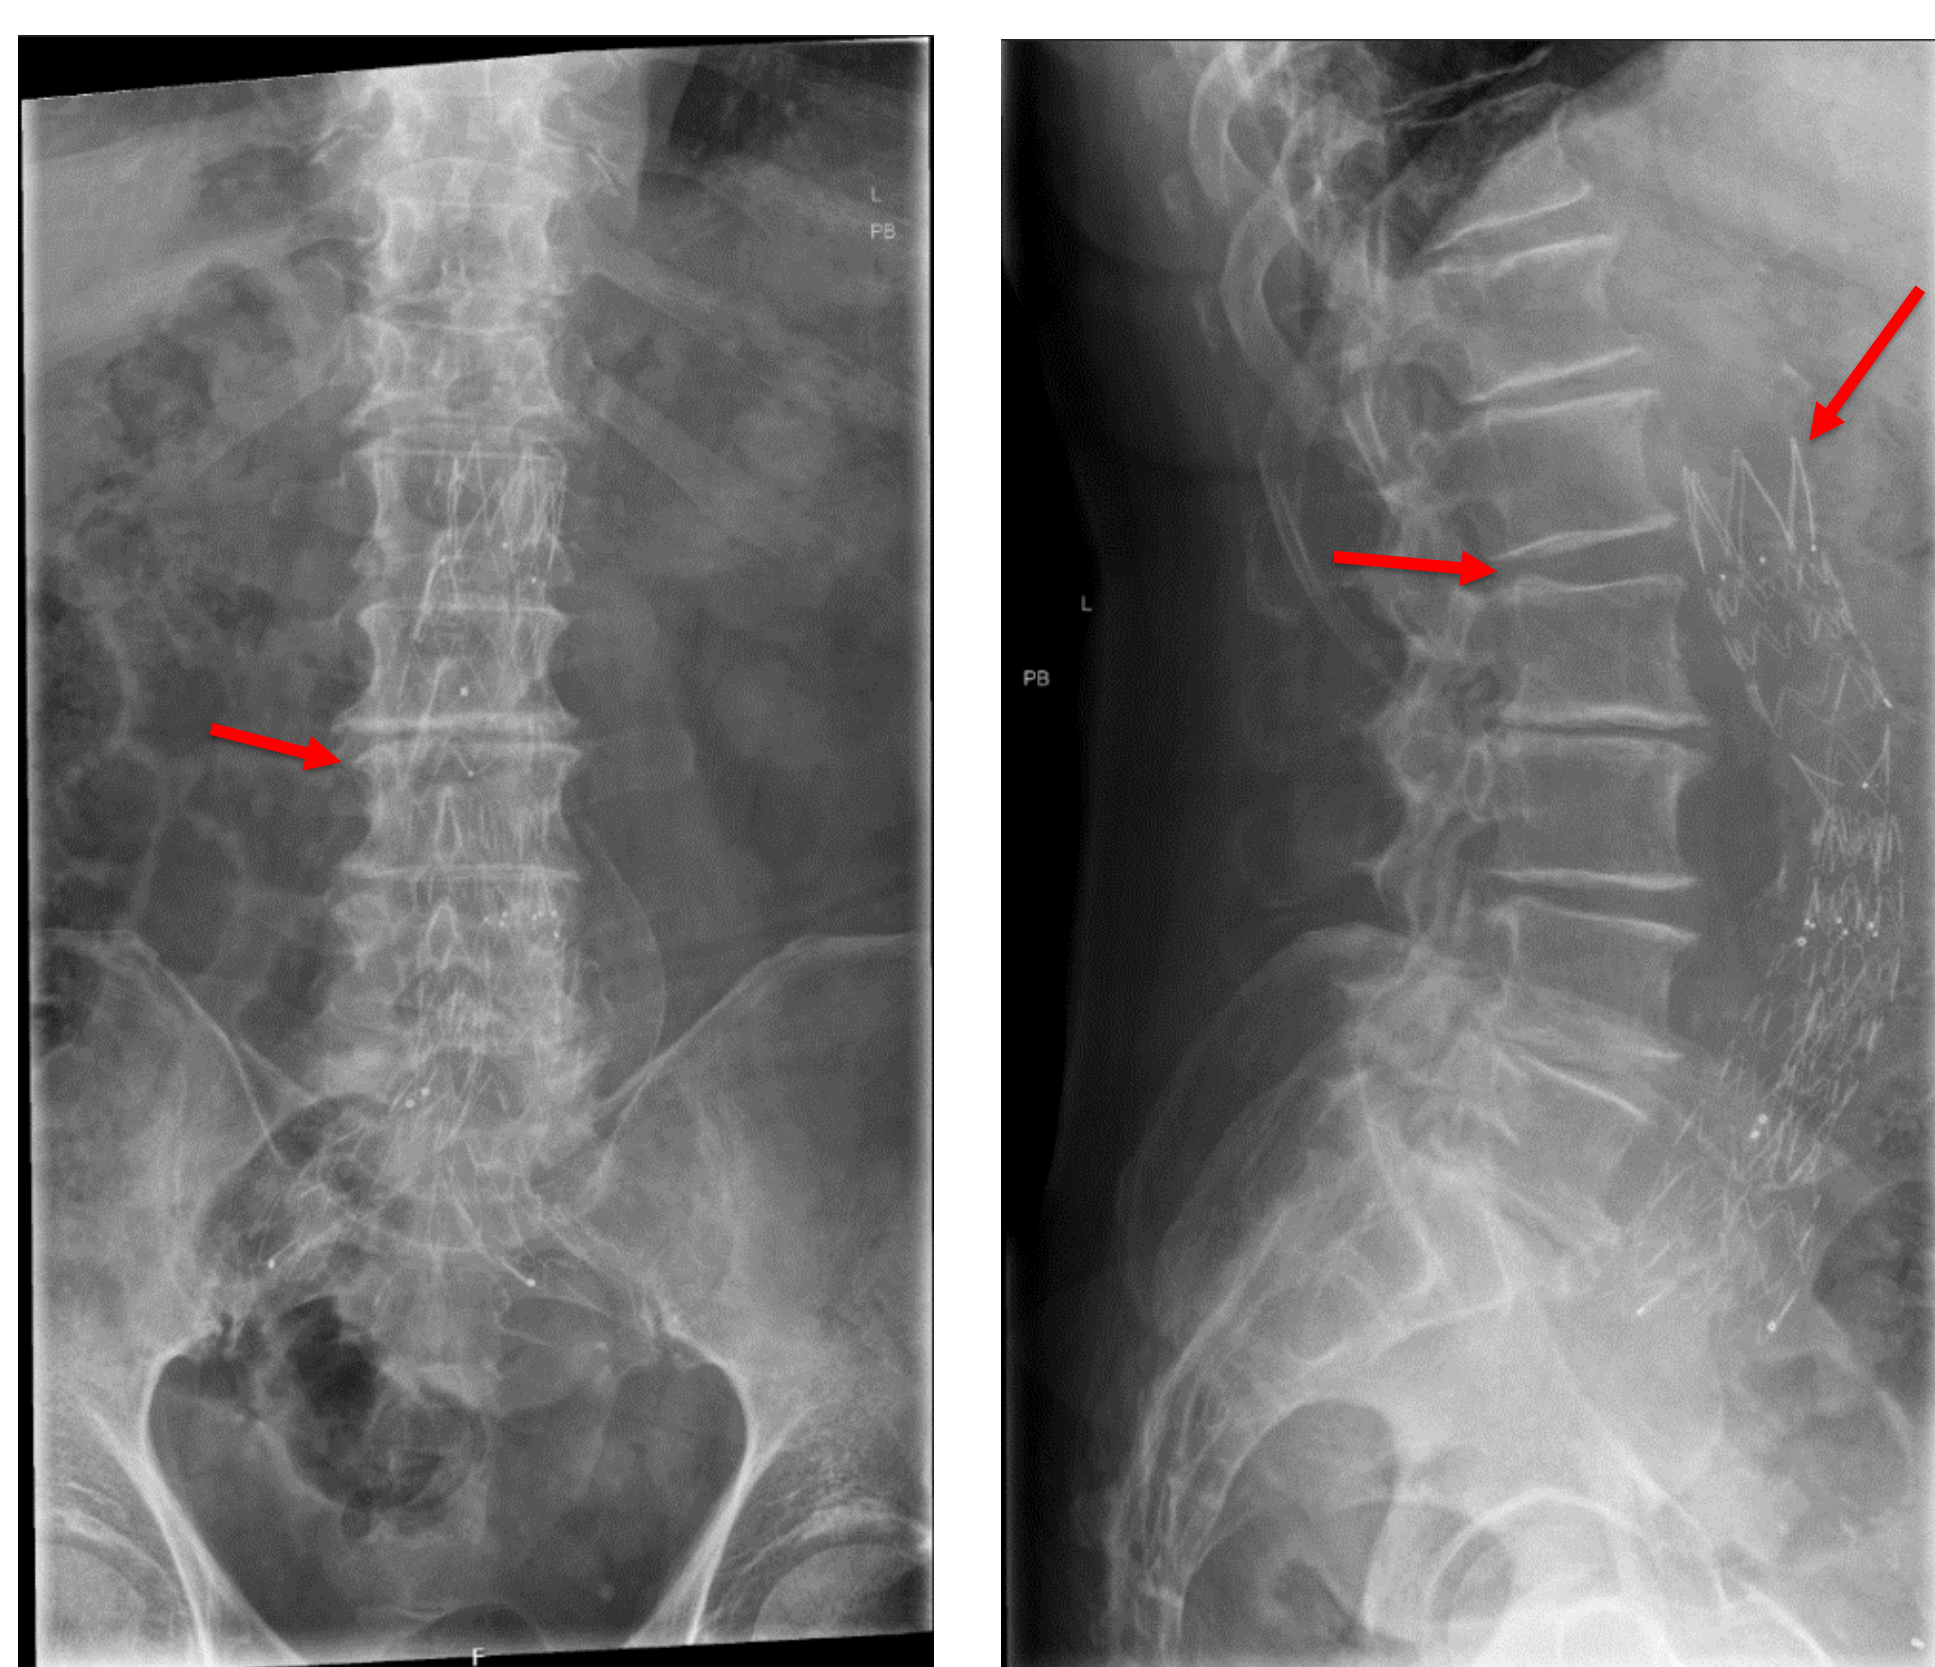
Lumbar spine plain radiographs on presentation. 22<sup>nd</sup> Jan 2024
